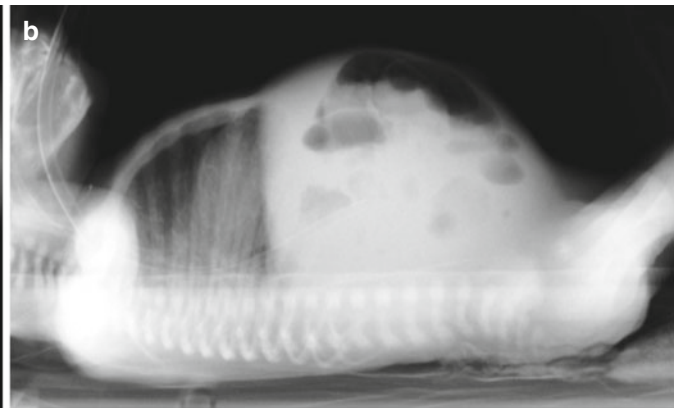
Abdominal plain film in newborn with NEC: (a) loss of mosaic aspect of the loops that are dilated and have a horizontal position that maintain over the time “fixed loops sign.” (b) There is also a condition of pneumoperitoneum
